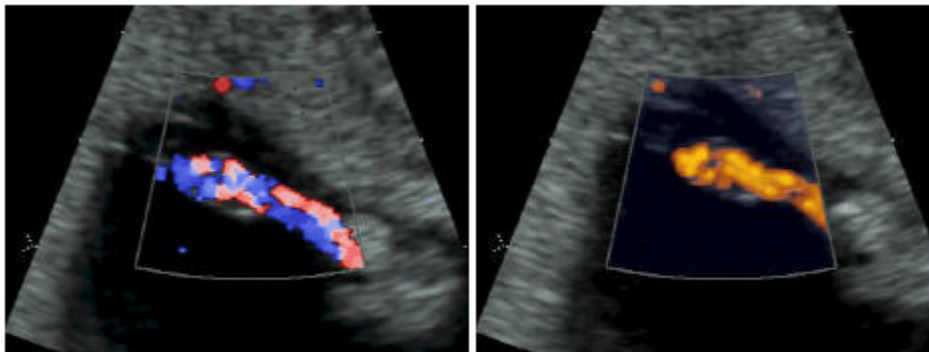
Color Doppler, and energy Doppler demonstrate a 2 vessel cord in a 10 week fetus.
